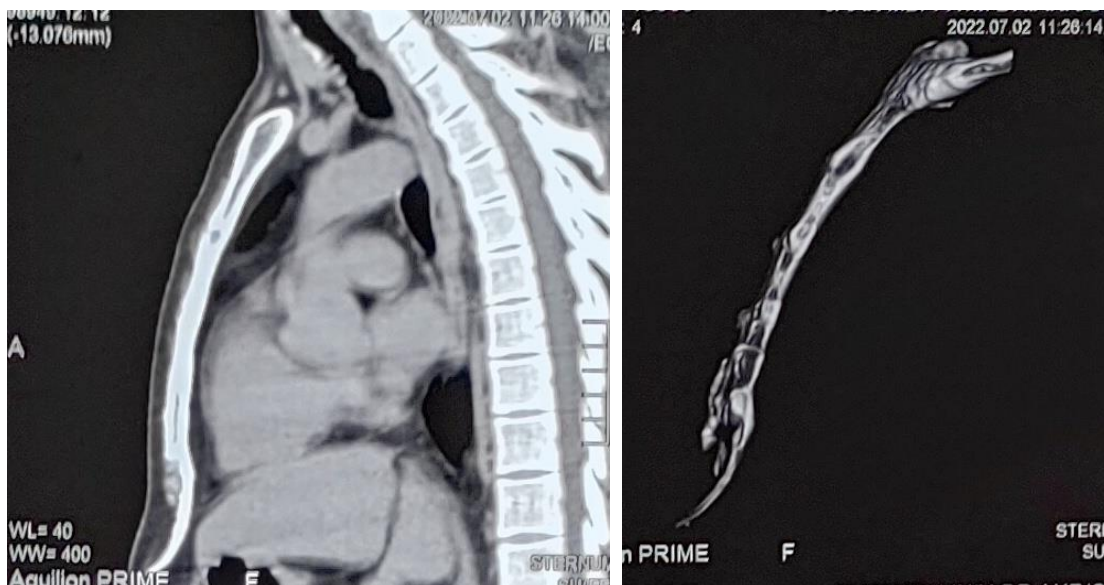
CT scan sagittal section and 3D image showing ventrally curved xiphoid process
